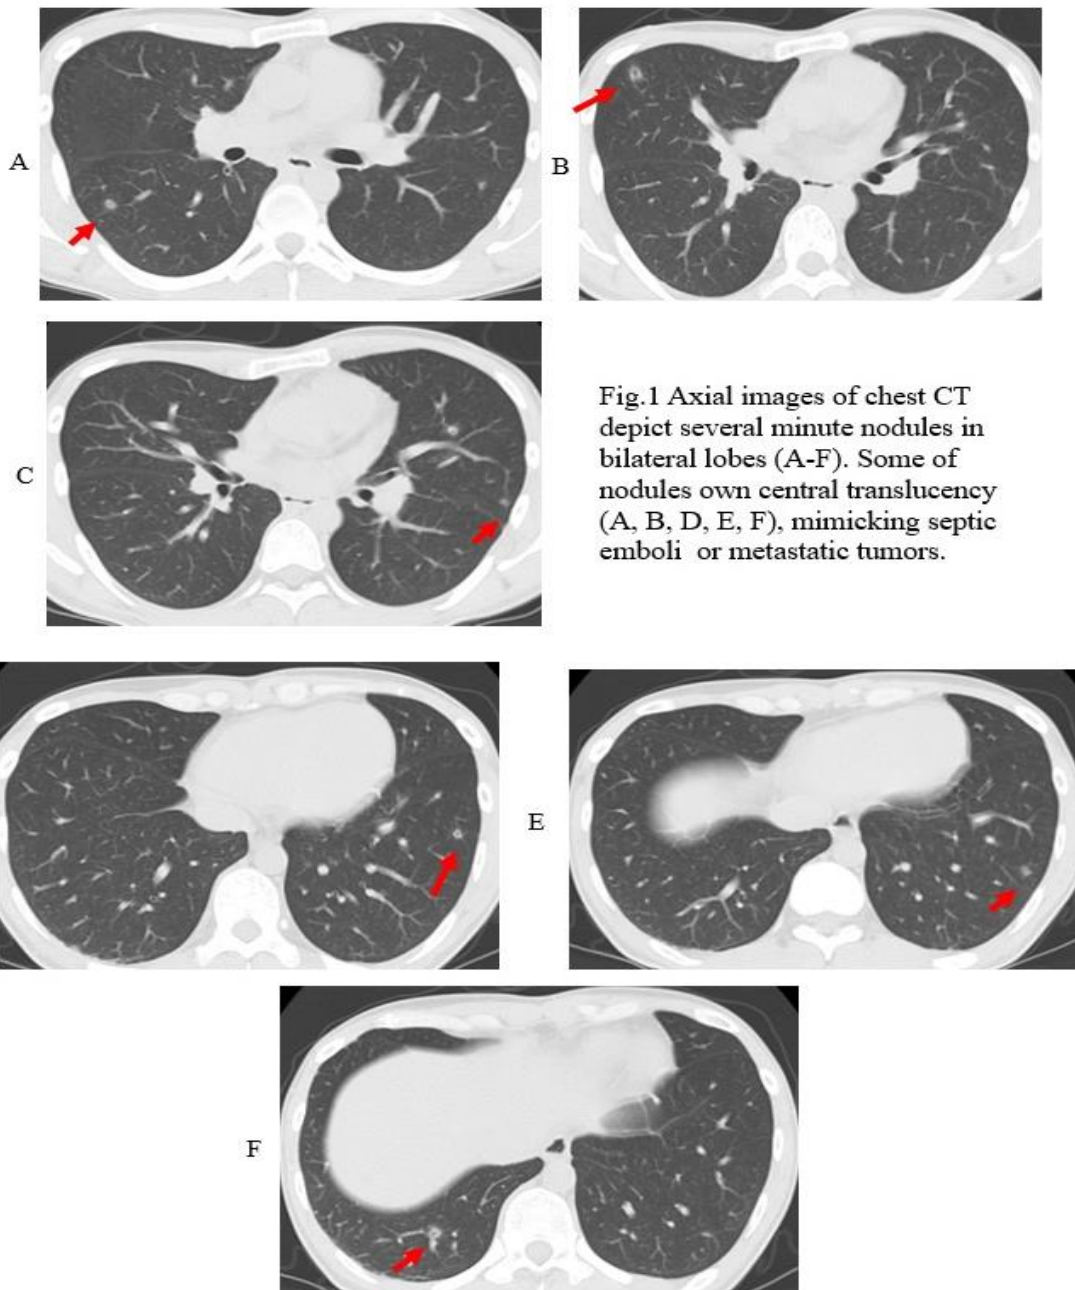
Axial images of chest CT depict several minute nodules in bilateral lobes (A-F). Some of nodules own central translucency (A, B, D, E, F), mimicking septic emboli or metastatic tumors.
